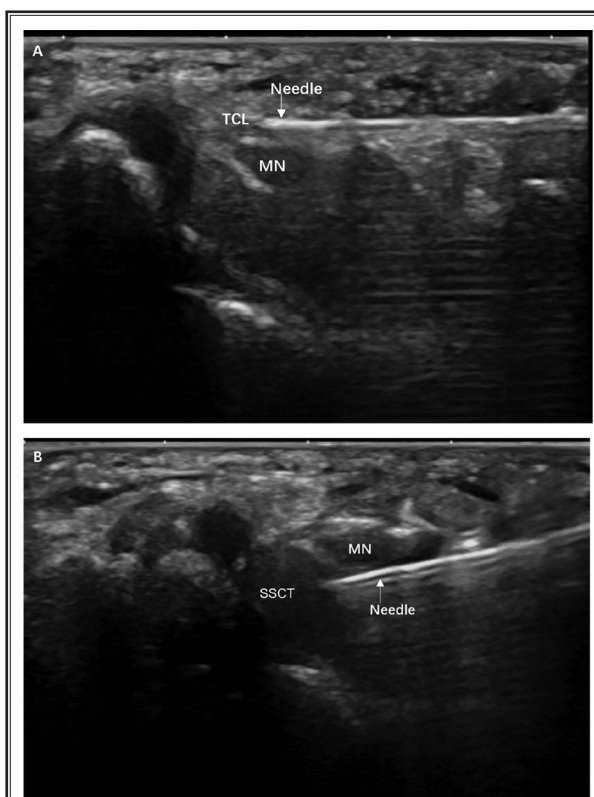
A) Ultrasound-guided TCL needle release via short-axis approach. B) Ultrasound-guided SSCT release via short-axis approach.*
